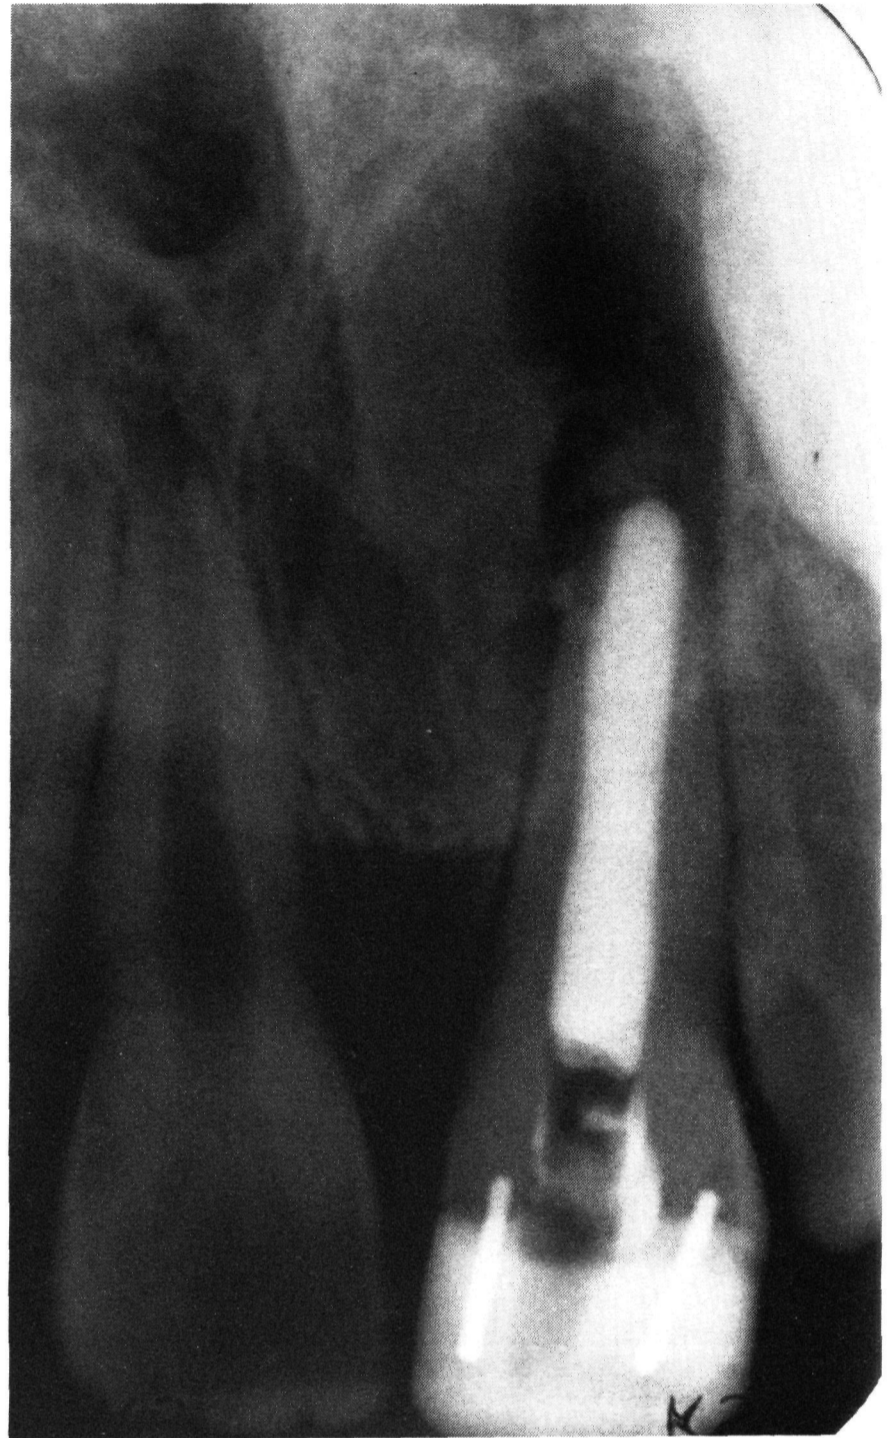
Same case as in Fig. 1 showing postobturation radiograph. The canal was filled with vertically condensed warmed gutta-percha. The radiolucent lesion has not resolved but an apical barrier has formed.
